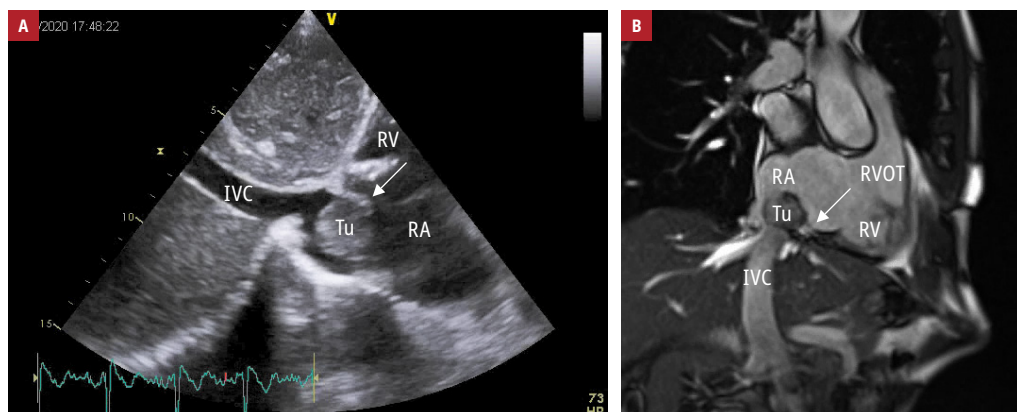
A – echocardiography, subcostal short-axis view; B – cardiac magnetic resonance, sagittal plane; arrows indicate the pedunculus of the tumor
